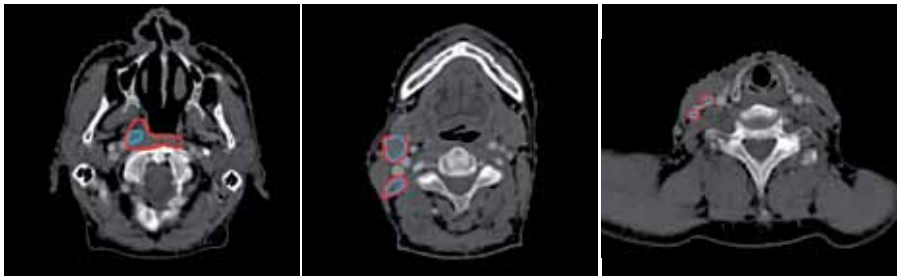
A–C: Transaxial CT images (same as above) showing the GTV delineated on PET/CT (GTV PET, blue lines) and the final GTV (red lines).
